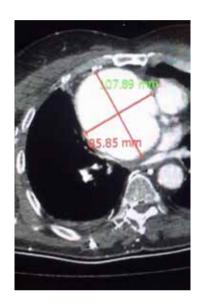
Axial C+ CT Angiography Arterial Phase: The aneurysmal dilatation of the ascending aorta with no intimal calcification or perianeurysmal leakage, approximately 11x8.5cm in diameter at the upper mediastinal level.
